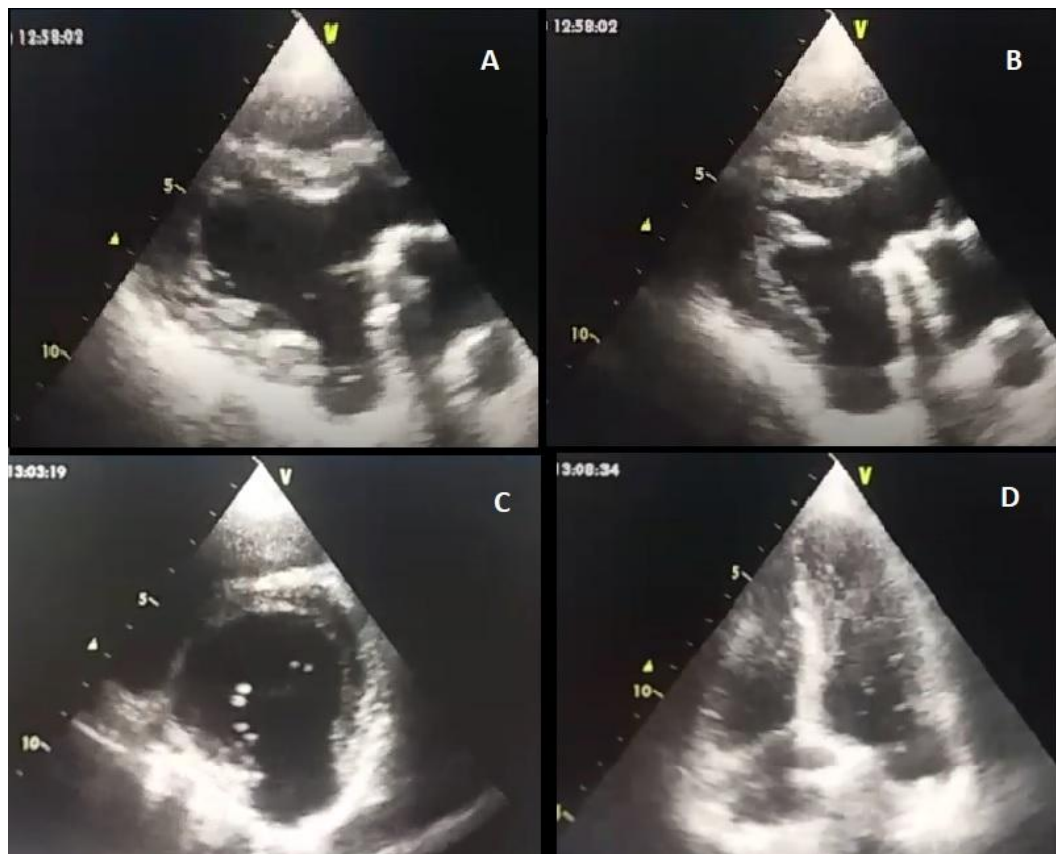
Transthoracic echocardiography (A) Parasternal long axis view during diastole (B) Parasternal long axis view during systole (C) parasternal short axis view (D) Apical 4 chamber view: showing the addition image with LV posterior wall discontinuity suggestive of LV pseudoaneurysm.
